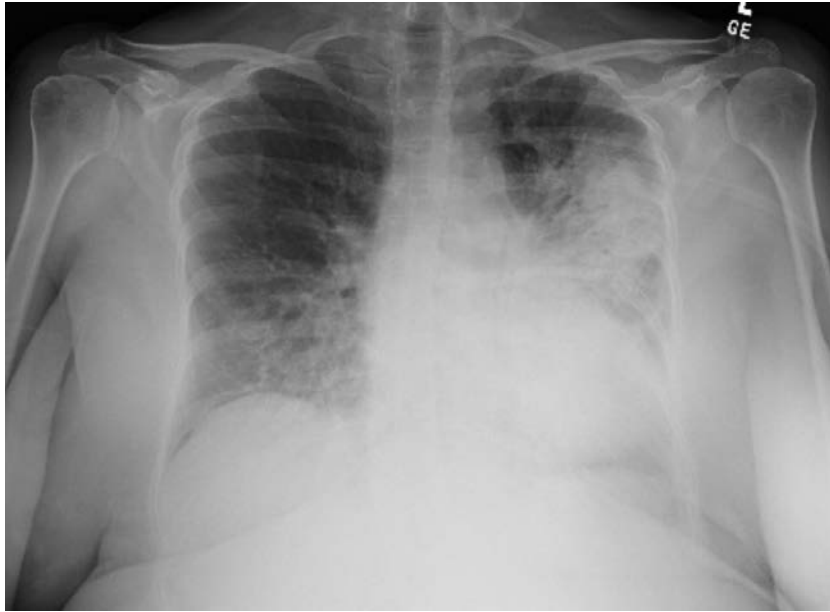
Chest radiograph on initial presentation
